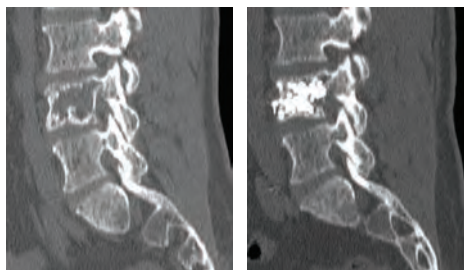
Percutaneous vertebroplasty in a metastatic vertebra with impending fracture. Lytic lesion in vertebral body (a), postoperative x-ray following the vertebroplasty (b).
